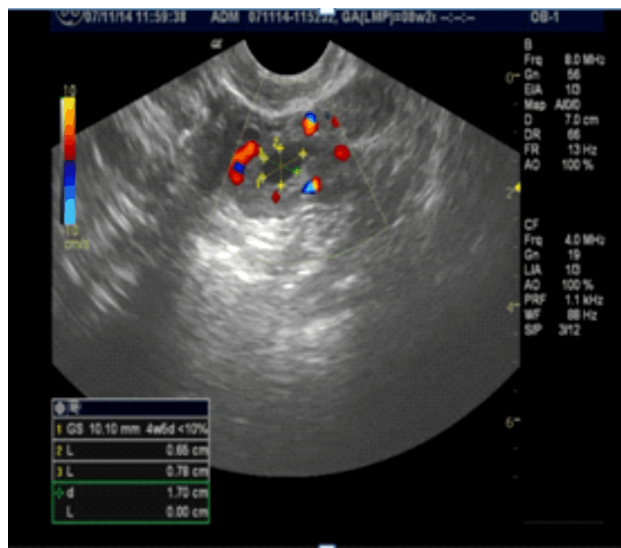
Transvaginal ultrasound image of an ectopic tubal pregnancy: a mass with a hyperechoic ring around the gestational sac (10 mm – four weeks and five days); empty adnexal gestation sac.
